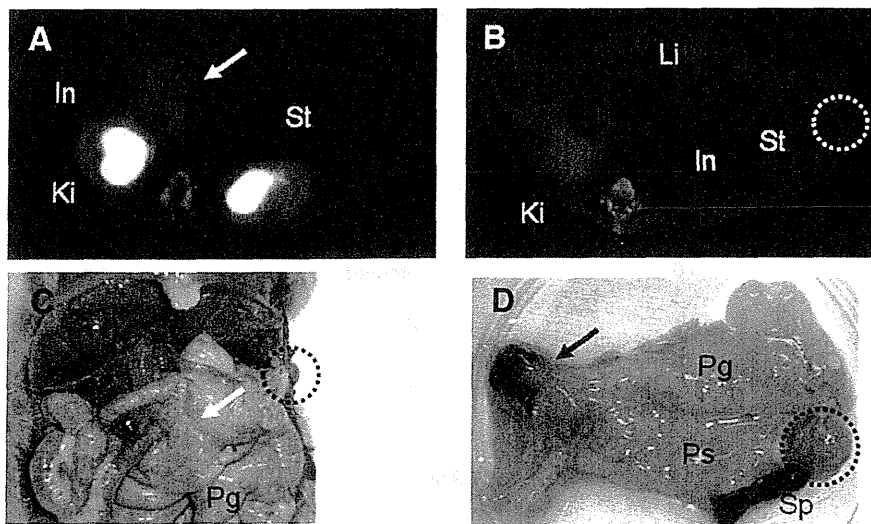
(A and B) SPECT axial images of pancreatic tumor (A) and purulent inflammatory lesion (B) in hamster 10. (C and D) Anatomic images of abdomen (C) and excised pancreas (D). Tumor (8 mm) in pancreatic head is indicated by arrow. Inflammatory lesion is indicated by dotted circle. In = intestine; Ki = kidney; Li = liver; Pg = pancreatic gastric lobe; Ps = pancreatic splenic lobe; Sp = spleen; St = stomach.
